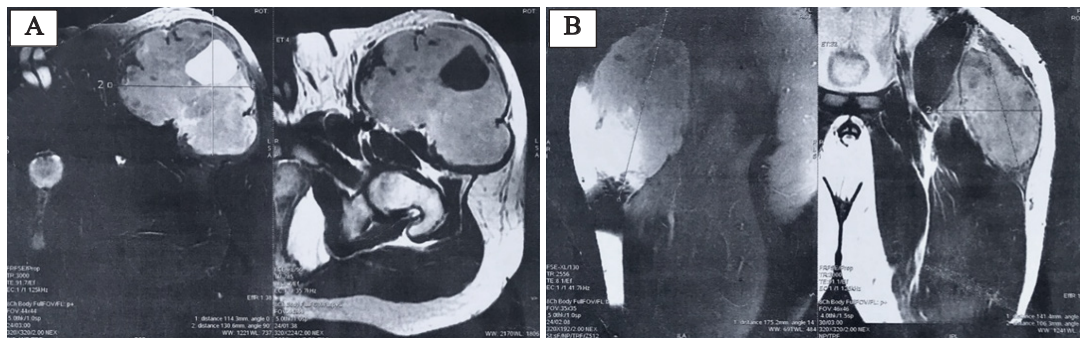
(A) Axial view of the pelvic MRI before the first surgery & (B) Coronal view showed suggestive of malignant intramuscular mass
